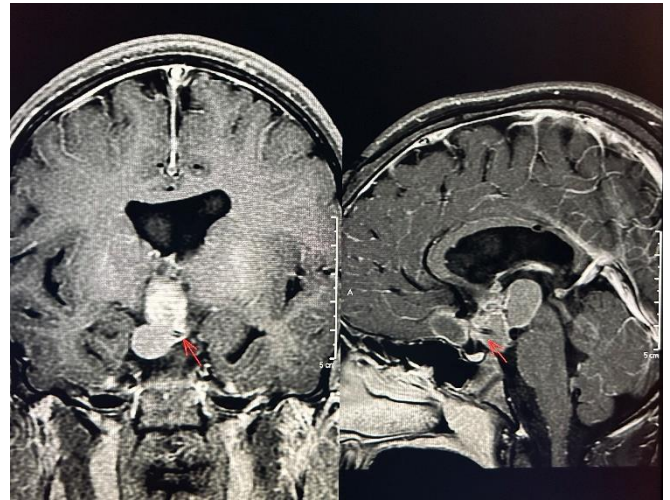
Magnetic resonance imaging of the brain (GE 1.5 Tesla) on contrast-enhanced T1-weighted (axial and sagittal) sequence showing a new increase in the solid-cystic sellar and suprasellar image accompanied by a change in the image signal approximately two years after the use of alpha interferon via the Ommaya catheter reservoir. The tip of the arrow indicates the positioning of the catheter.
